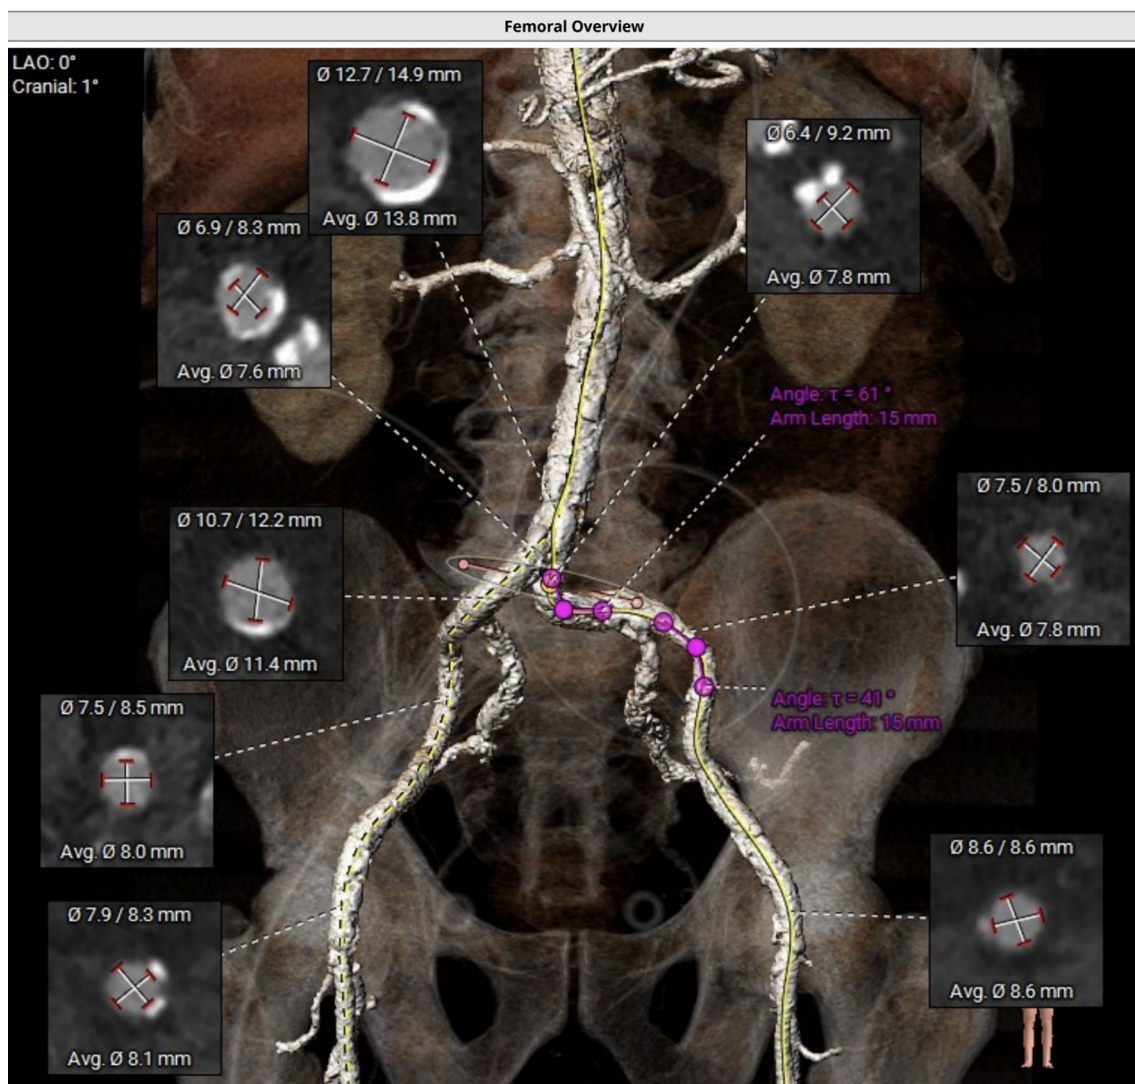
CT imaging of lower extremity arteries
